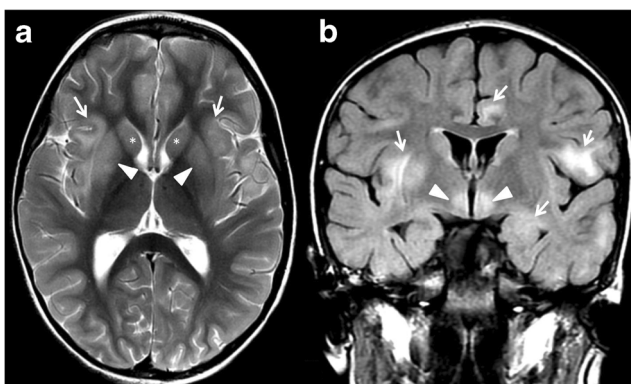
A 6-year-old male suffering from acute disseminated encephalomyelitis (ADEM). Bilateral hyperintensity of the basal putamen (a, *arrowheads*) and caudate nucleus (a, *asterisks*) is noted on axial T2-weighted images. Multifocal involvement of the cortex more prominent in the frontal-insular regions is identified (a, b *arrows*). Bilateral hypothalamic hyperintensities are identified on coronal FLAIR images (b, *arrowheads*). MRI changes of ADEM are usually reversible
